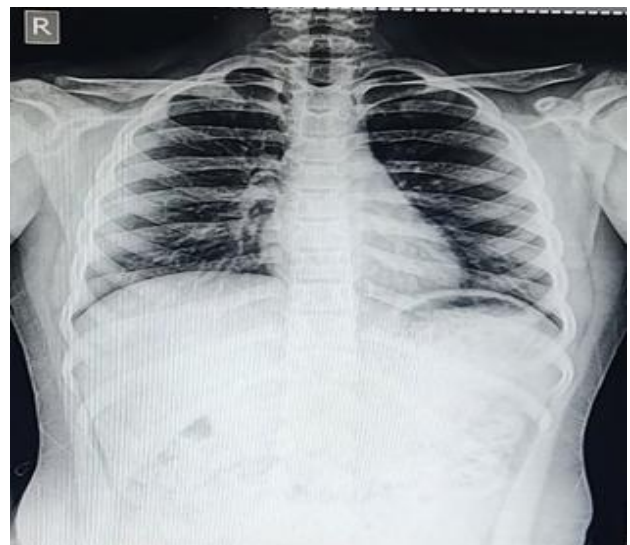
X-ray chest posterior-anterior view after extraction of foreign body.
